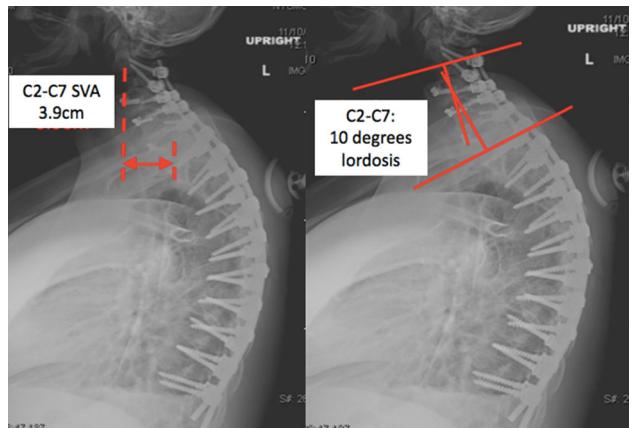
Postoperative radiograph demonstrating significant improvement in coronal and sagittal alignment
